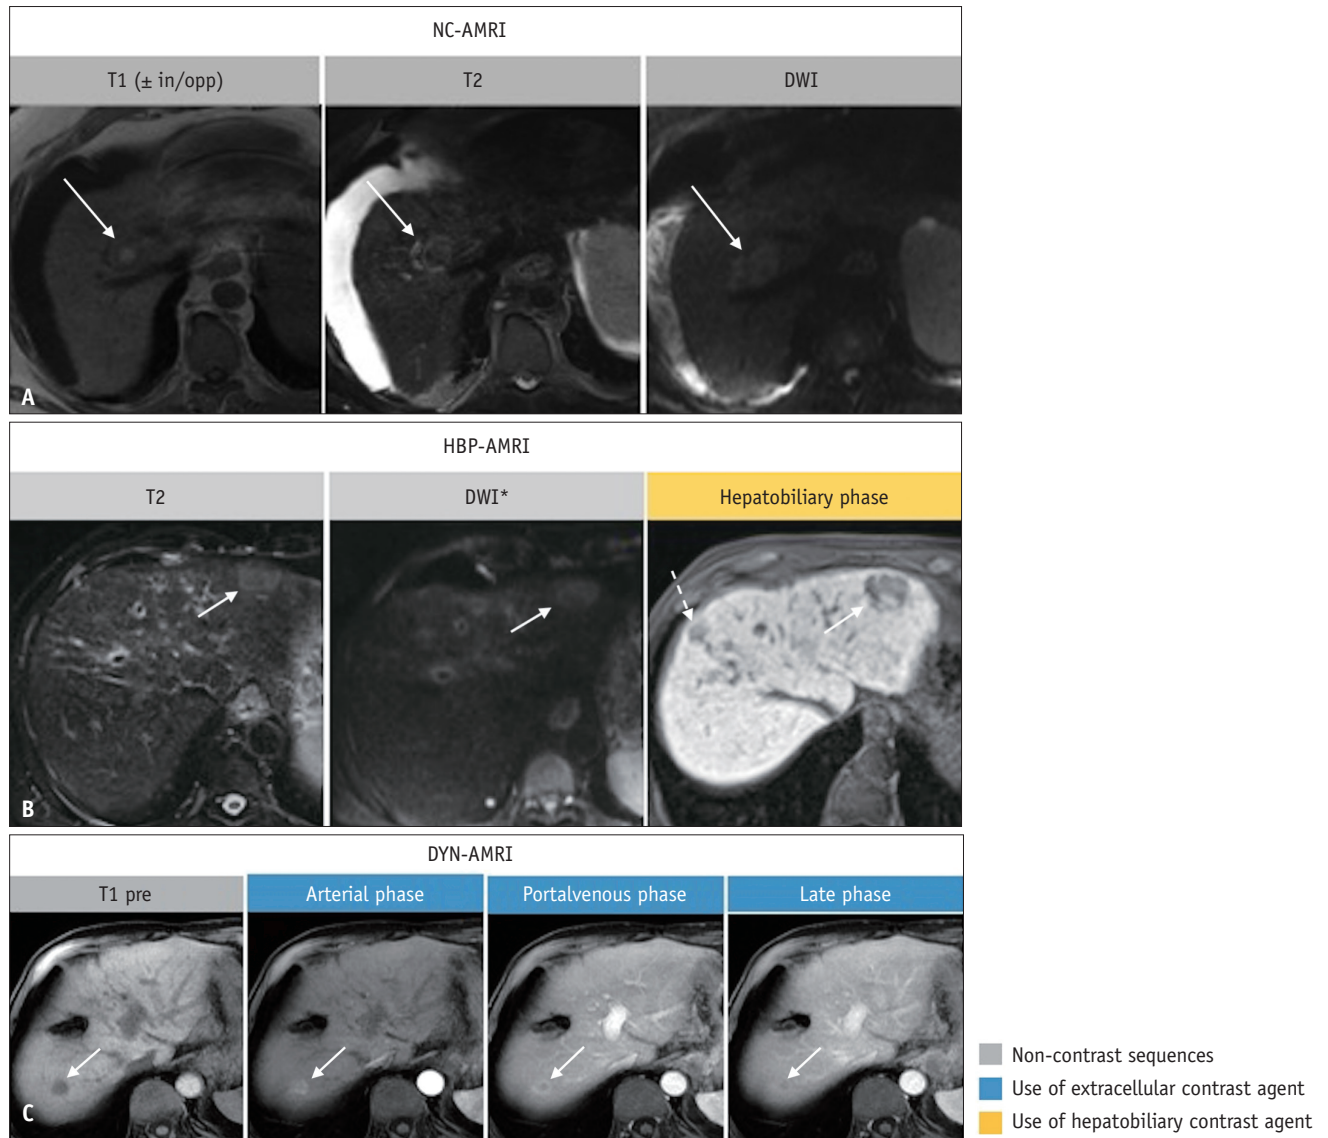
Abbreviated magnetic resonance imaging (AMRI) in three different patients with hepatocellular carcinoma. Non-contrast (NC)-AMRI (A), hepatobiliary (HBP)-AMRI (B) and dynamic (DYN)-AMRI (C) in three different patients with hepatocellular carcinoma (arrows in A-C). In the hepatobiliary phase an additional lesion can be appreciated (dashed arrow in B). *There is no consensus on whether diffusion-weighted imaging (DWI) should be a part of this protocol or not. in/opp = in and opposed phase imaging, pre = pre-contrast
